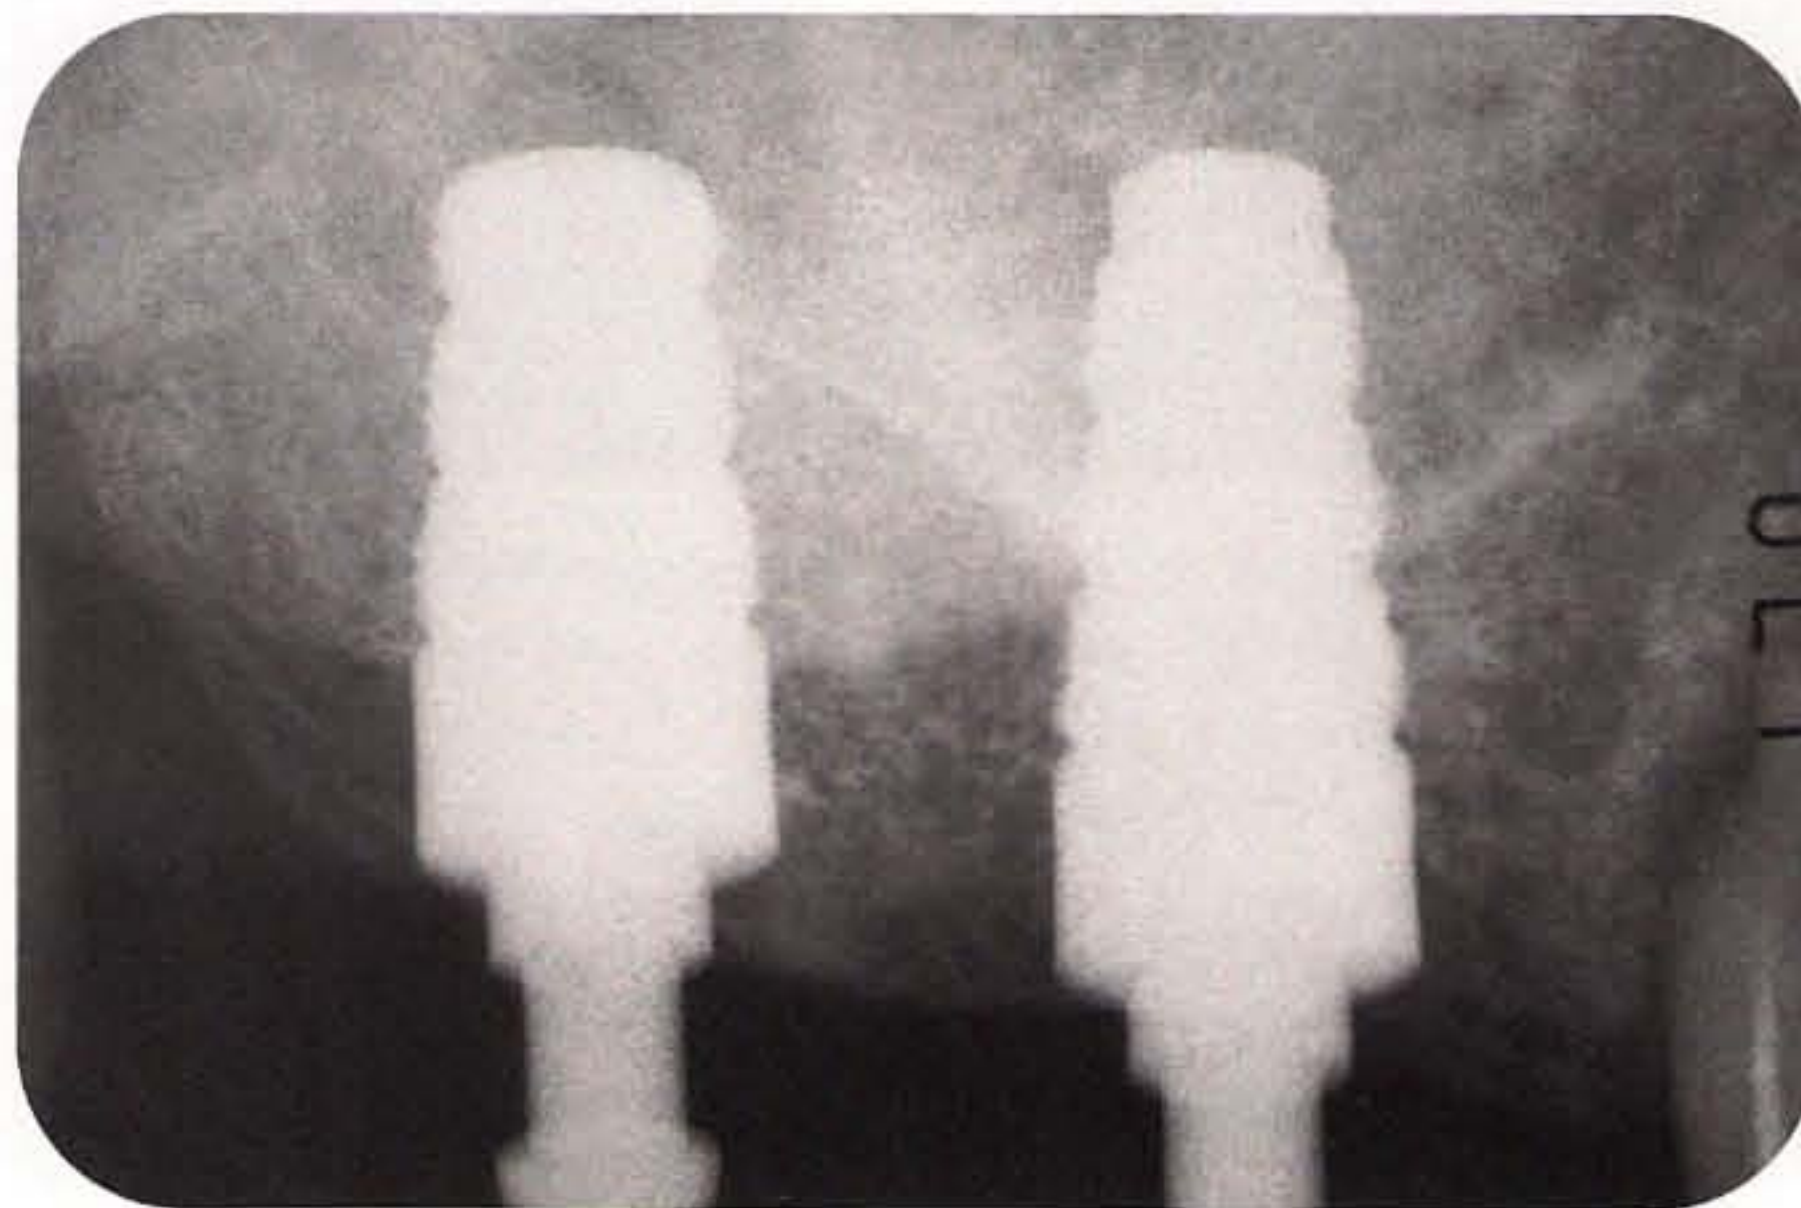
Radiograph to verify the correct placement of implants in the molar area. The radiograph reveals the correct positioning of the implants in relation to the alveolar crest. In addition, the sinus floor elevation, about 6 to 7 mm in the region of the first molar and 3 mm in the area of the second molar, is visible. The technique known as *localized management of sinus floor* was used.
